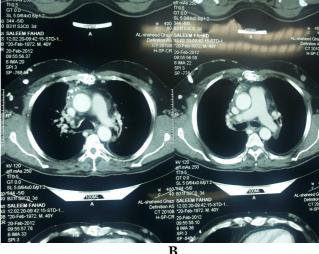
Three-dimensional venographic and reconstruction computed tomography scan of the same patient; (A) Widespread arrangement of collateral circulation due to obstruction of the right and left brachiocephalic vein that extended toward the chest wall; (B) Soft tissue density and calcifications adjacent to the superior vena cava and great vessels
